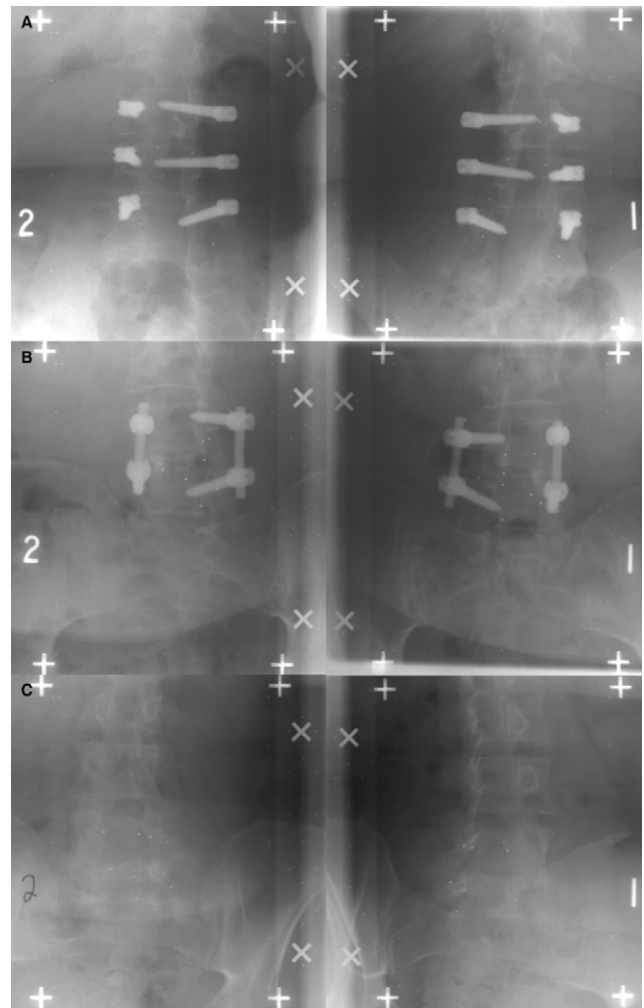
Selected examples of biplanar radiographic images for RSA of lumbar dynamic stabilization (A), posterolateral fusion and instrumentation (B), and discectomy (C).
